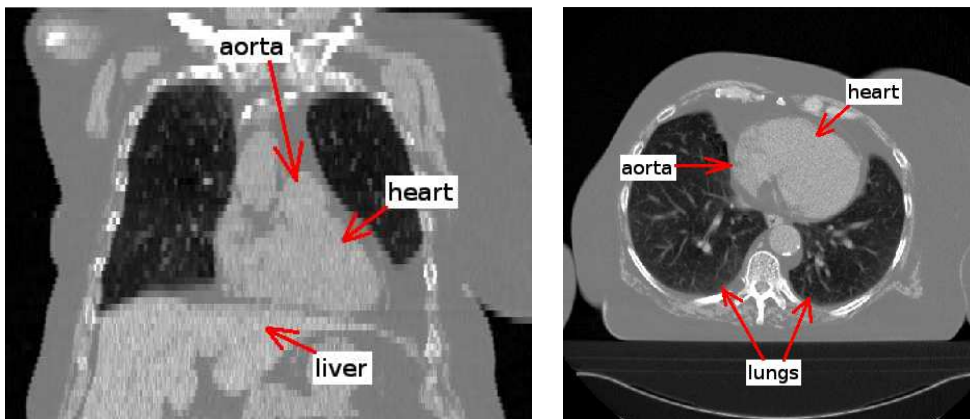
Coronal (left) and axial (right) views of a CT image.
